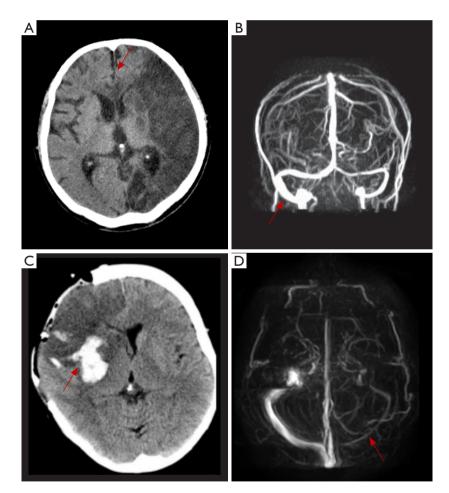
Primary endpoint events, secondary endpoint events, and TS variants in patients with anterior circulation infarction. CT scan of the head of a 75-year-old male showing a malignant middle cerebral artery infarction with a midline shift of more than 10 mm (A, arrow), and a MRV scan showing ipsilateral TS developmental variation (B, arrow). The CT scan of the head of a 62-year-old male showing a combined hemorrhagic transformation after an anterior circulation infarction (C, arrow), and a MRV scan showing a developmental variation of the contralateral TS (D, arrow). TS, transverse sinus; MRV, magnetic resonance venography.
